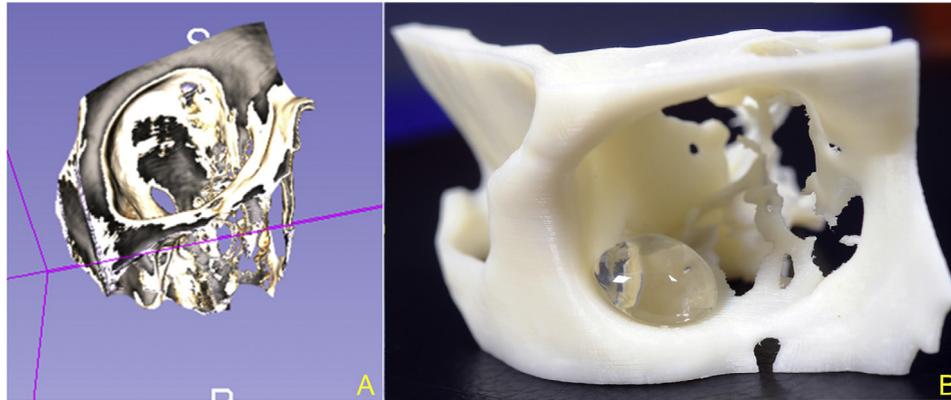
Skull models in soft copy and 3D. A: skull model built in 3D using DICOM images of the patients CT orbit, B: skull model printed in plastic and used as a mould to fabricate an orbital implant from PMMA.
